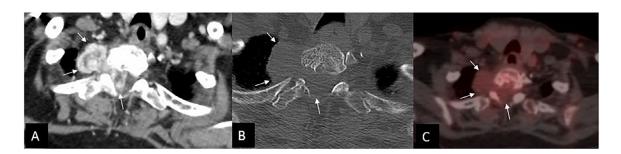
Initial imaging investigation. (A) Axial CT with contrast revealing a dumbbell-shaped heterogeneously enhancing epidural mass with right paraspinal extension, (B) Axial unenhanced CT bone window showing prominent trabeculae in the vertebral body and lamina of T1, and (C) FDG-PET revealing mild avidity within the lesion. The extent of the mass is marked with arrows.
